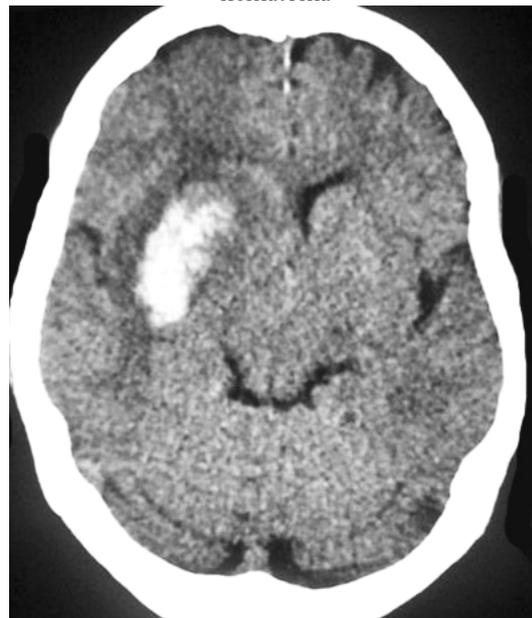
CT image of basal ganglia hematoma
